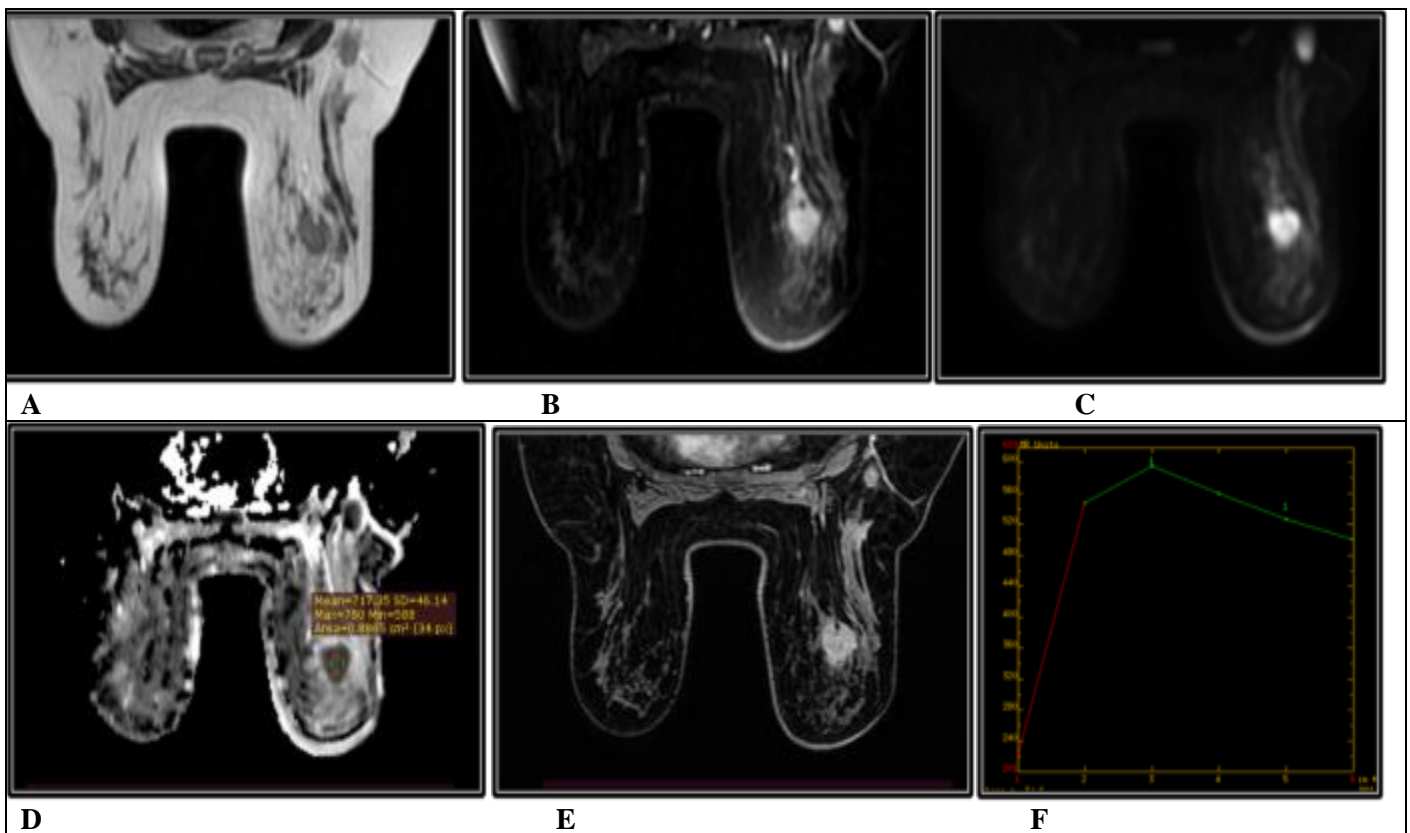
Case 1, Right breast invasive ductal carcinoma in a 45-year-old female patient. (A) Axial T2WI shows an ill-defined mass with spiculated margins at the upper outer quadrant of the right breast (opposite 11 O'clock) displaying isointense signal to the surrounding glandular tissues. (B) Axial STIR shows hyperintense signal to the surrounding glandular tissues. (C) Axial DWI sequence (b= 1000) shows hyperintense signal. (D) Axial ADC map shows hypointense signal denoting restricted diffusion with calculated mean ADC value = $0.72 \times 10^{-3} \text{ mm}^2/\text{s}$. (E) In post-contrast series, the mass displays heterogenous enhancement. (F) Time-signal intensity curve reveals type III curve (wash-out pattern). The mass was correctly classified as malignant (BIRADS 5) according to combined imaging protocol.
